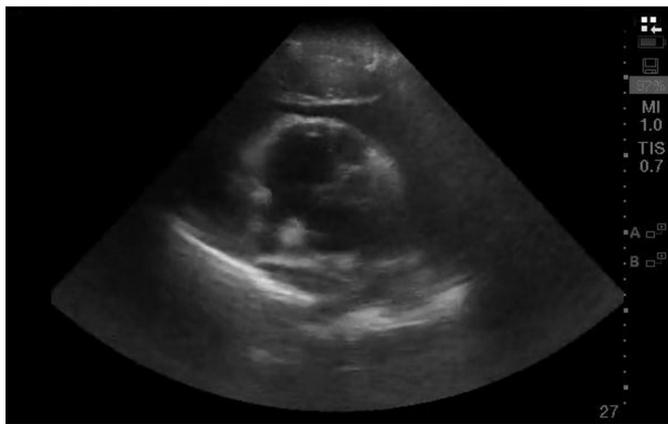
Bedside transthoracic echo in a parasternal long view showing pericardial effusion with right ventricular collapse.
